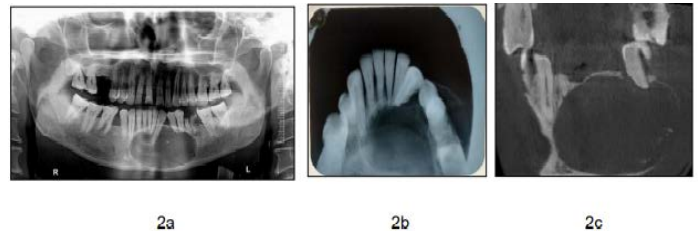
panoramic radiograph showing unilocular radiolucent lesion with corticated borders.
